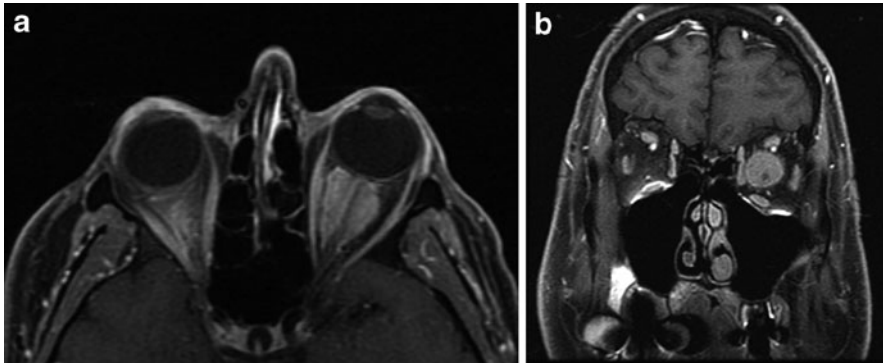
MRI meningeoma OS (post-gadolinium): (a) axial and (b) coronal
